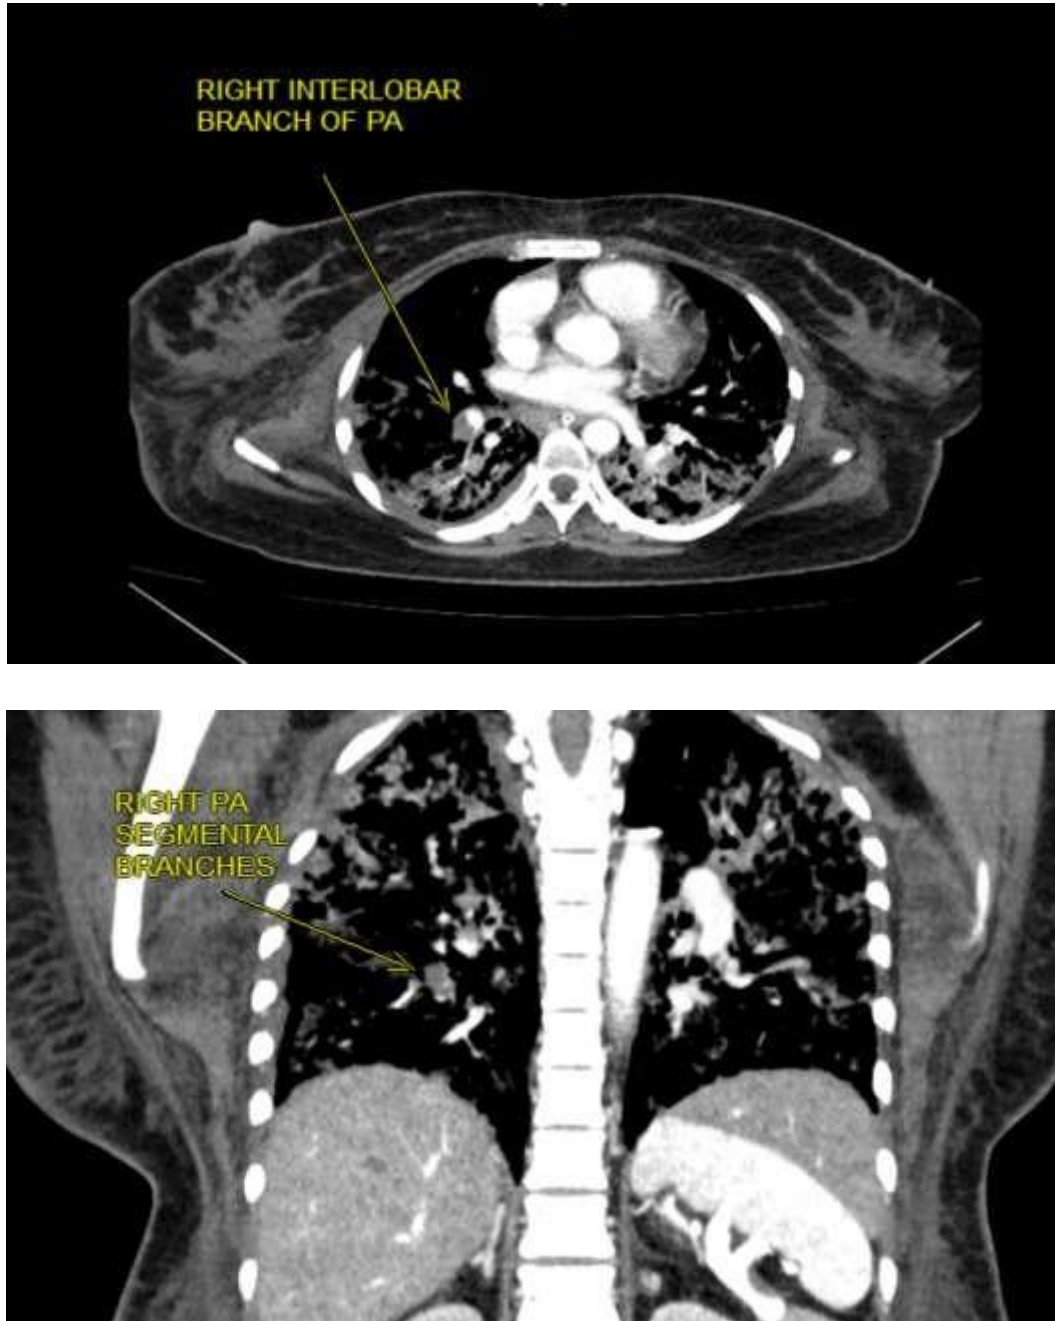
CT PULMONARY ANGIOGRAM (CORONAL AND AXIAL) OF COVID-19 PATIENT DEMONSTRATING ACUTE PULMONARY THROMBOEMBOLISM INVOLVING INTERLOBAR AND SEGMENTAL BRANCHES OF RIGHT PULMONARY ARTERY.
